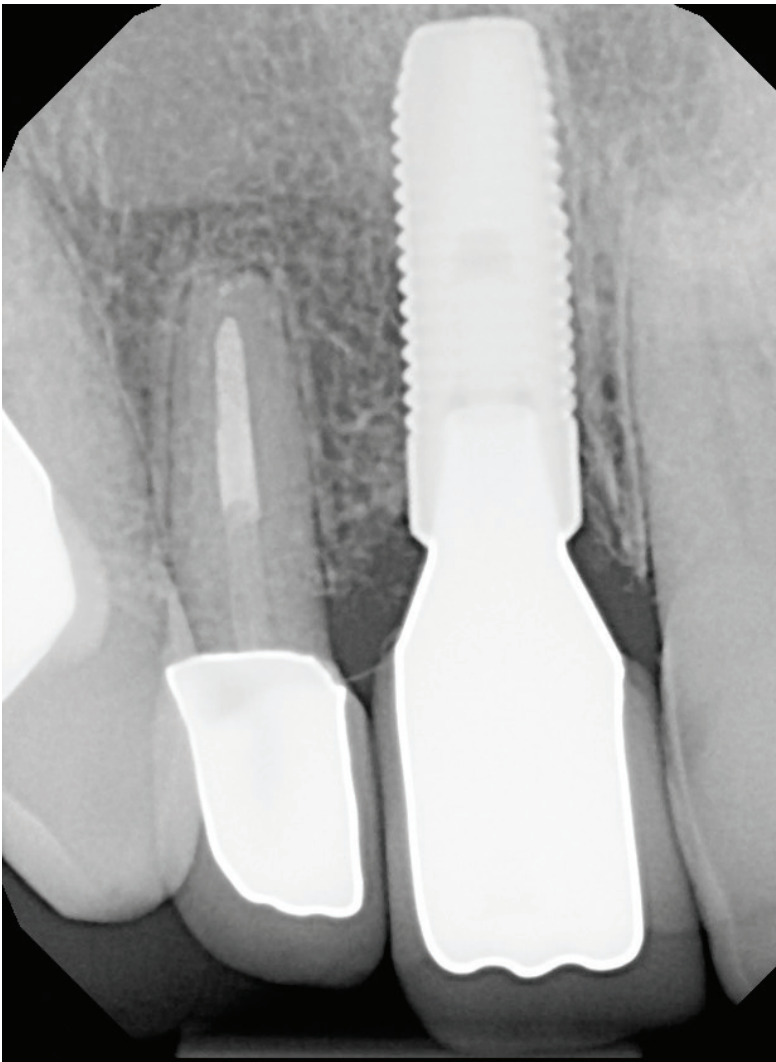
Radiograph of the final restorations.
